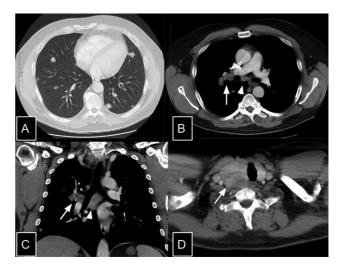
(A) (top left image): CT of the chest in the lung window at the level of the heart shows multiple bilateral pulmonary nodules in the right middle lobe, lingula, and left lower lobe. (B, C) (top right image [1B] and bottom left image [1C]): CT chest in mediastinal window demonstrates enlarged right hilar nodes (arrow) and subcarinal mediastinal node (arrowhead). (D) (bottom right image): CT chest in soft tissue window at the level of the lower neck shows an asymmetrically enlarged right lobe of thyroid with an ill-defined heterogeneous hypodense nodule (arrow).
